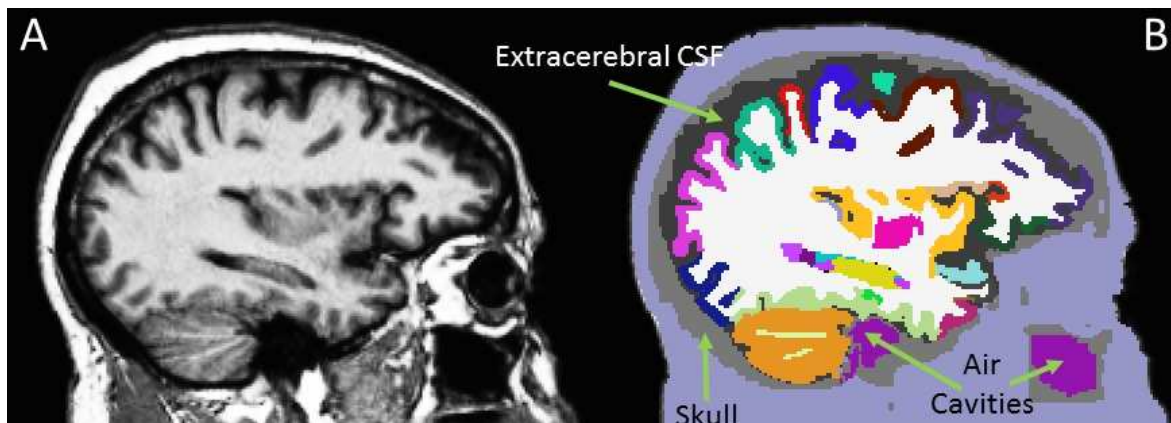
(A) Anatomical MRI (B) Whole head segmentation. Each color represents a different ROI including air cavities (e.g., sinuses), skull, and extracerebral CSF. Cerebral ROIs were created by the standard FreeSurfer analysis. The remainder of the head was modeled as a single ROI.
